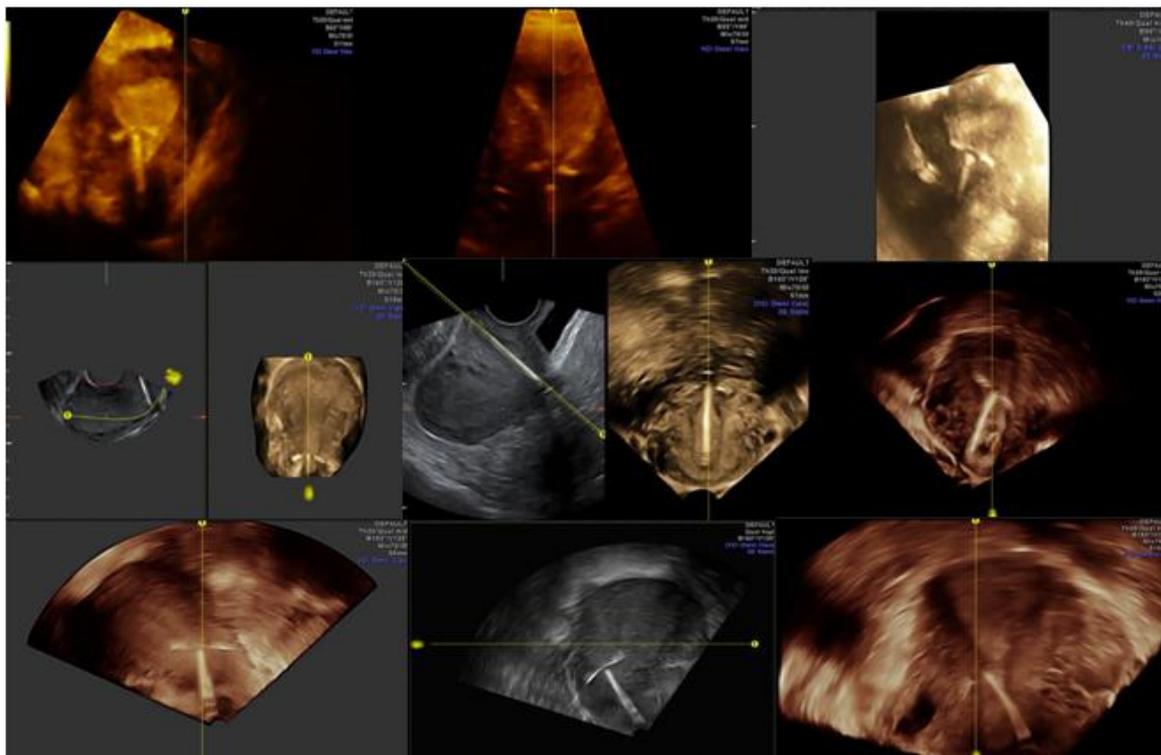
3D and Omniveiw VCI sonographic images for multiple cases with displaced and impeded one or both IUCD arms.
